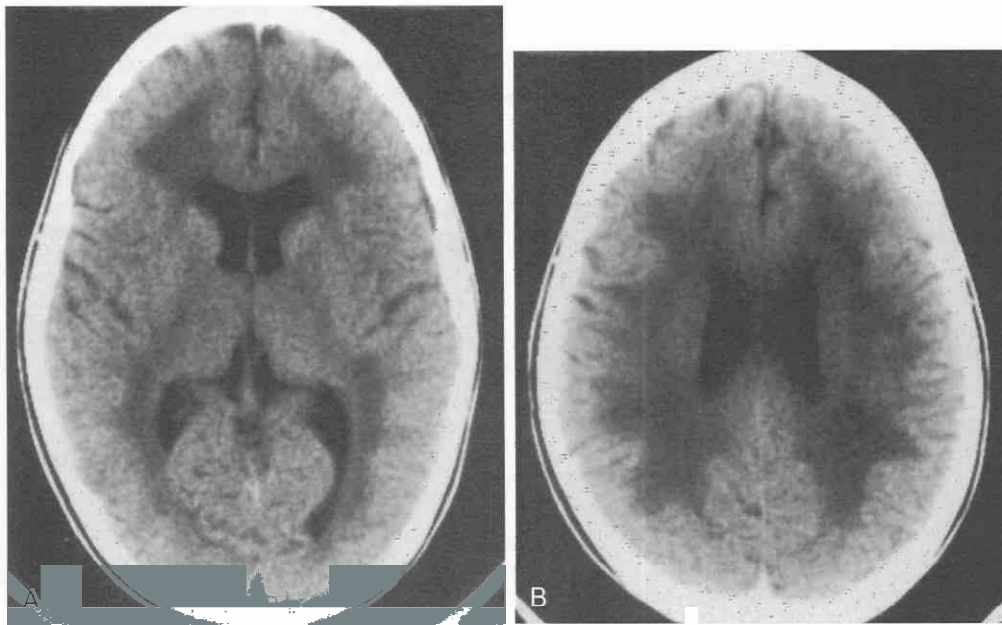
Myopathic carnitine deficiency in a 10-year-old boy with myopathy. Non-contrast-enhanced CT scans show diffuse, widespread, symmetrical lucency of the white matter, suggestive of demyelination.
